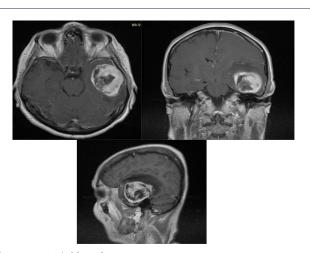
Initial head MRI.
